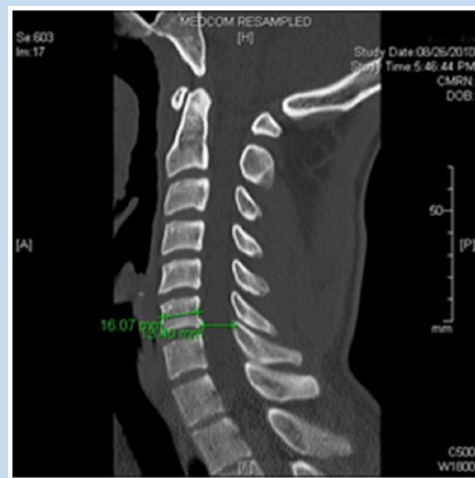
Immediate postinjury computed tomography scan demonstrating normal cervical spinal canal width and measurements for Torg ratio.
